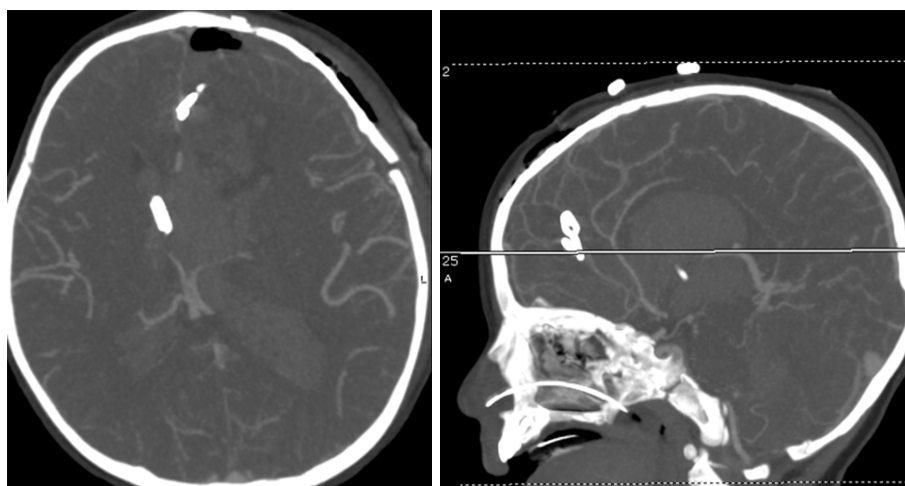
Postoperative computed tomography angiography of the head axial (left) and sagittal (right) with clips and no further aneurysm contrast opacification, suggestive of complete obliteration. An external ventricular drain is observed within the right frontal horn.
